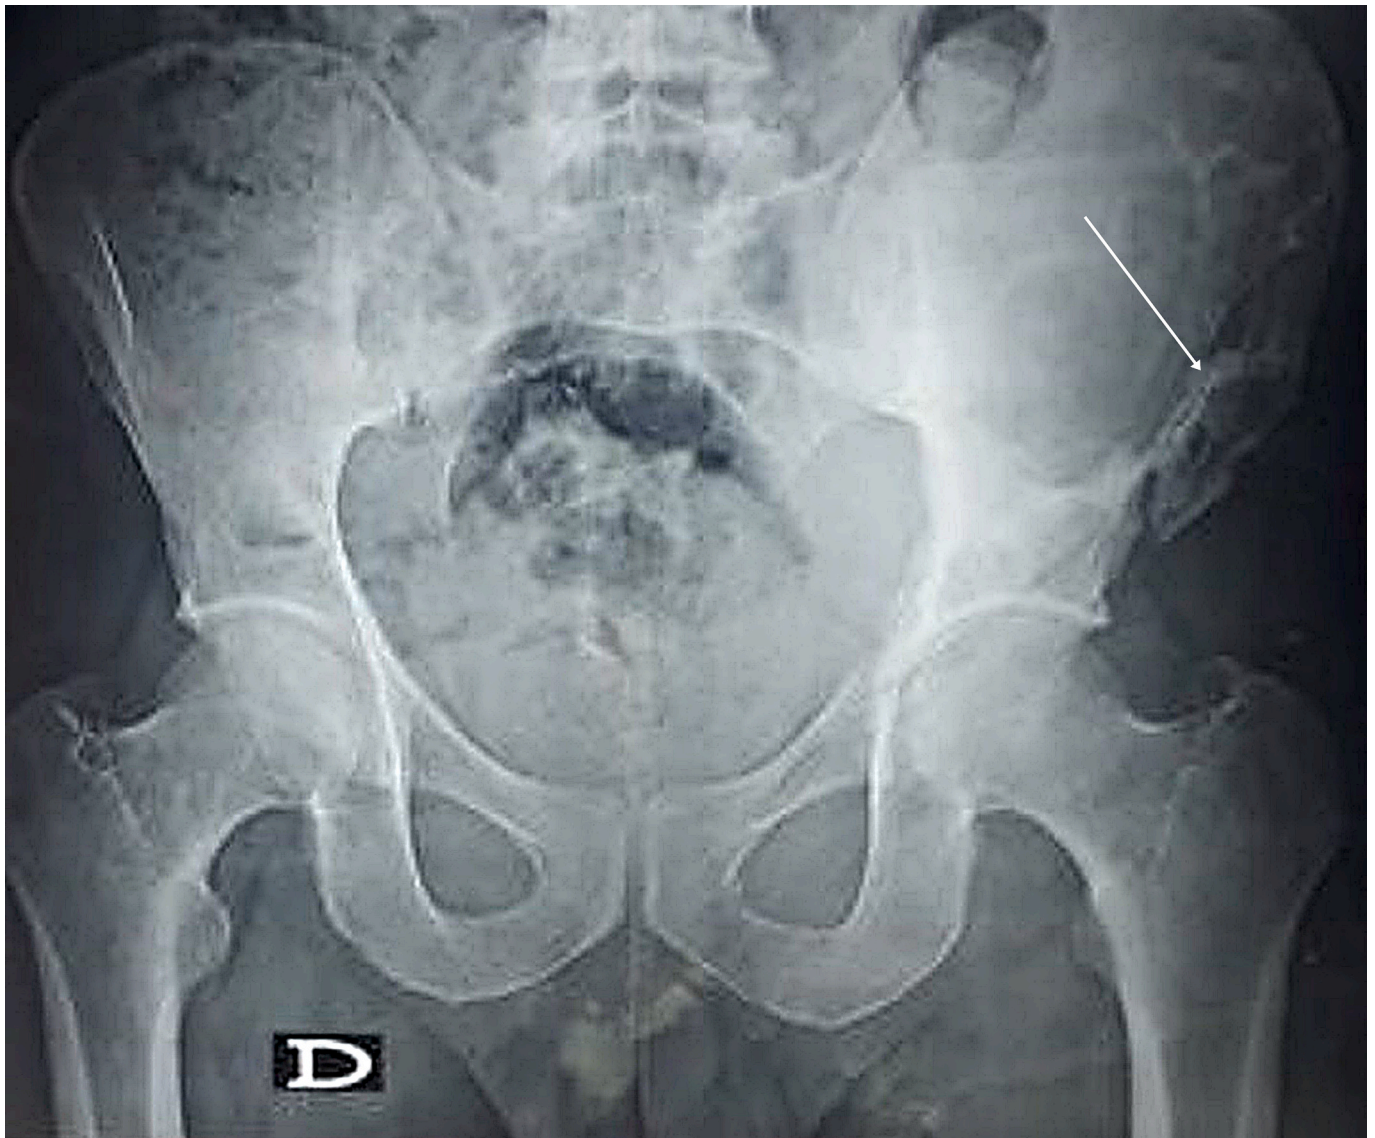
X-ray of the pelvis showing osteolysis of the left ilium (white arrow).
